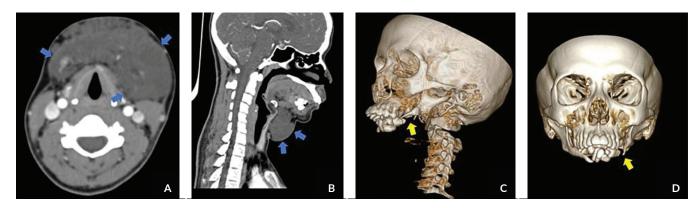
Computed tomography scans done in April 2019 with 3D reconstruction. Representative CT images showing a large, lobulated, non-enhancing, hypodense mass is seen at the submandibular to submental regions (blue arrows) in the axial plane (A) and sagittal plane (B). 3D bone reconstruction showing the extensive osteolysis of the left mandibular body (yellow arrows) as seen in the left anterior oblique view (C) and frontal view (D).
